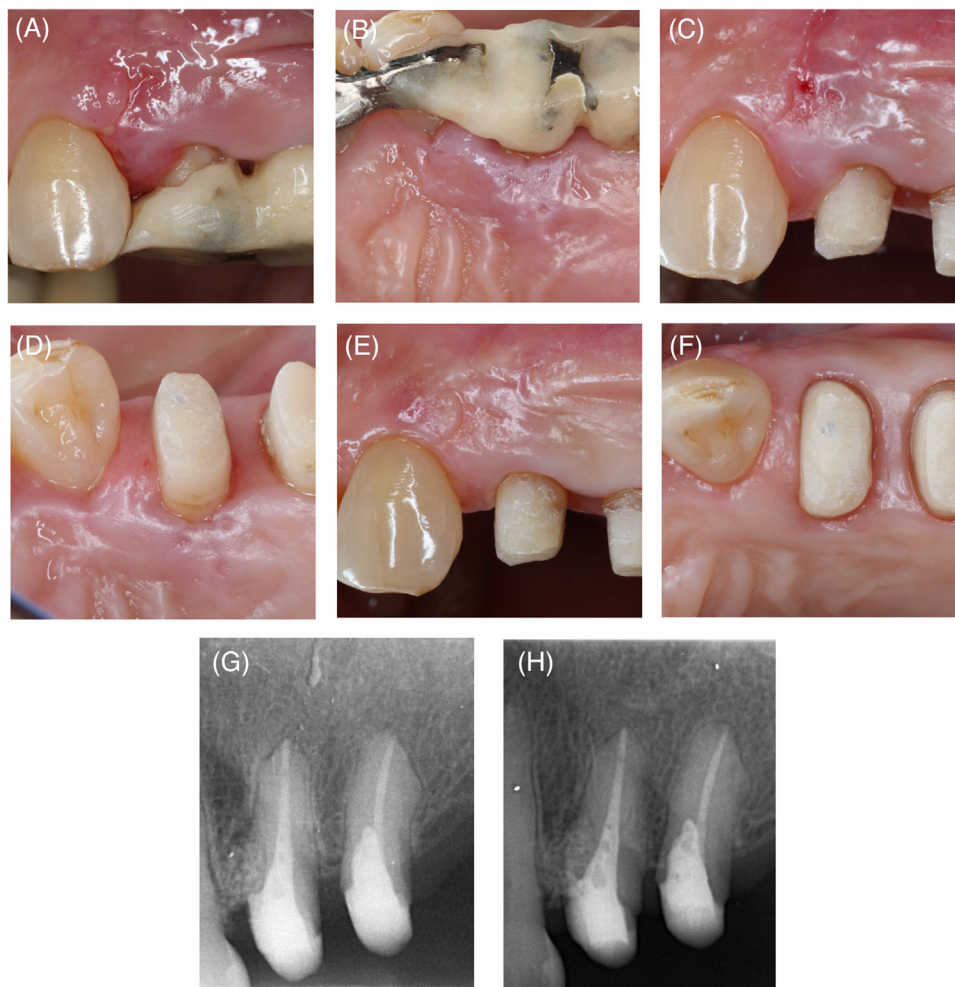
Postoperative clinical and radiographic images. At 1 week (A, B), 2 weeks (C, D), and 12 months (E, F). Dental X-ray images at 3 weeks (G) and 12 months postoperatively (H).
